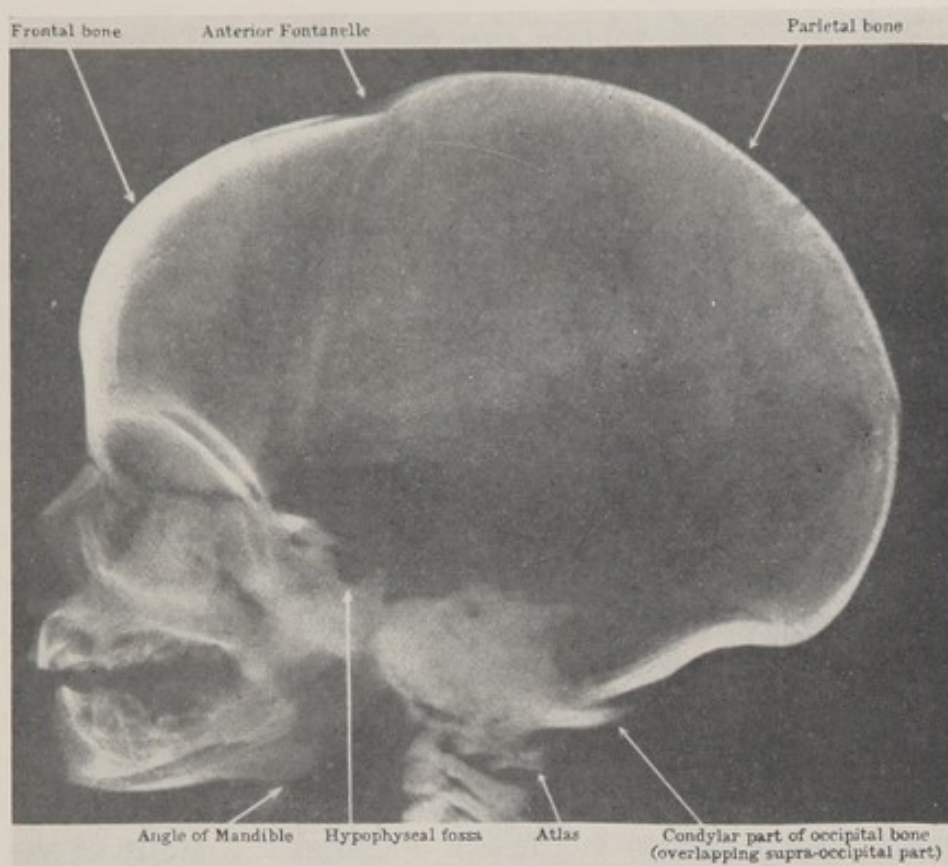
X-rays of normal skull and mongoloid shortly after birth. A. (Upper) Lateral view of full term fetus after Cunningham's *Textbook of Anatomy*. Note size and angulation of sphenoid body and plane of cribriform plate. Note development of nasion and maxilla.
